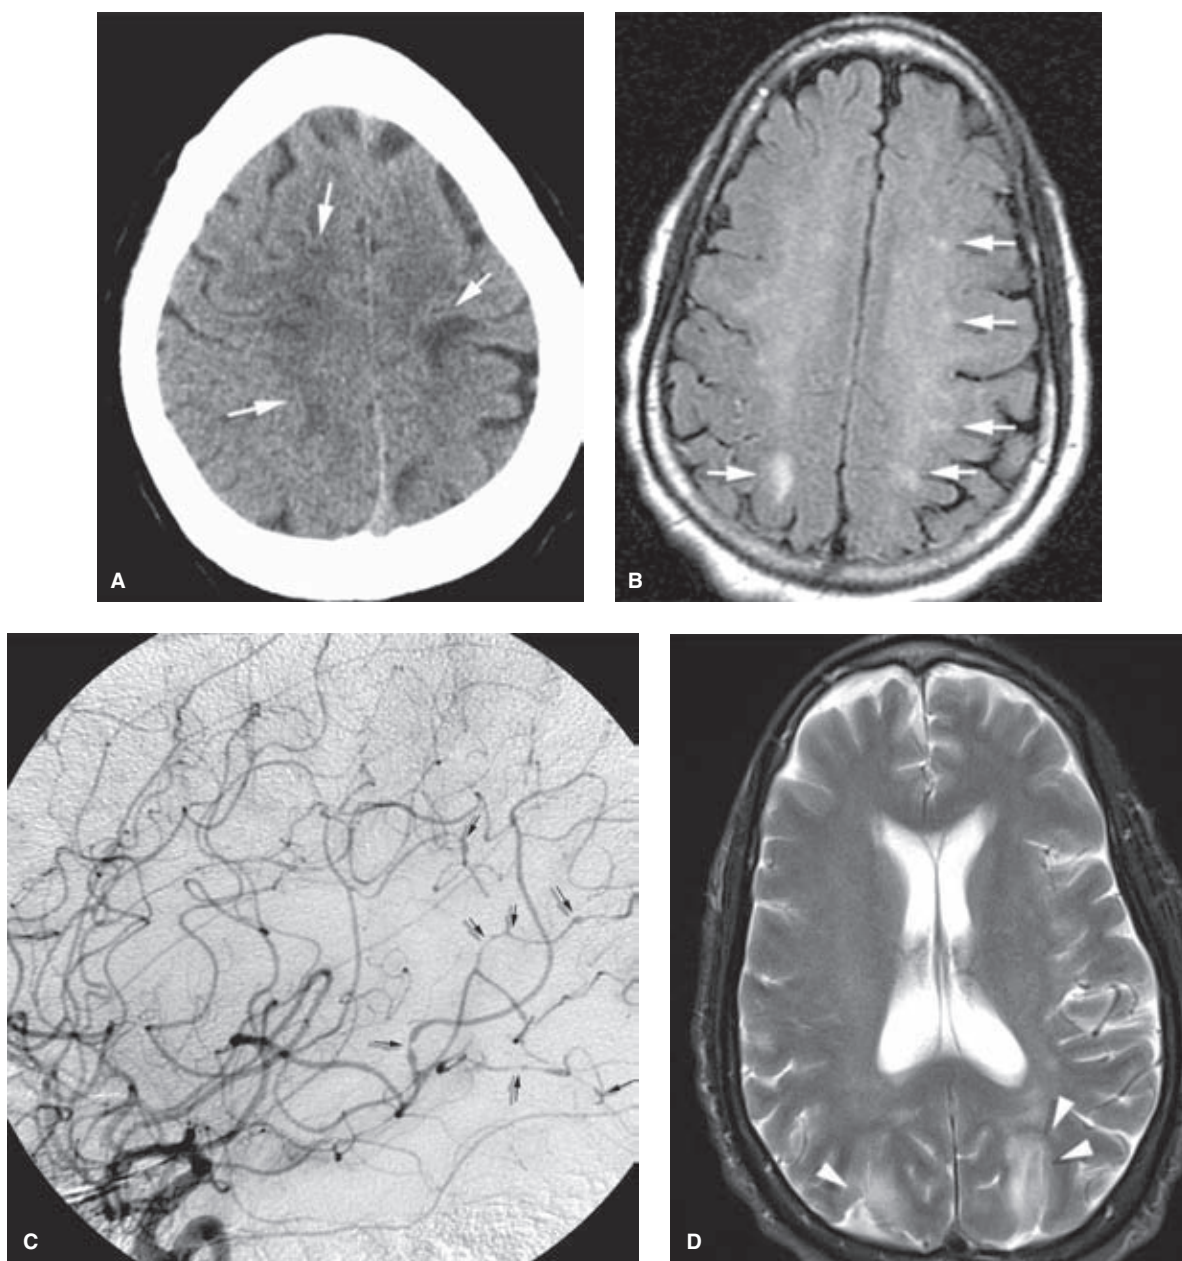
(A–D) RCVS associated with selective serotonin uptaker inhibitor use. A female patient in her sixties who had been prescribed an SSRI agent for treatment of depression presented with acute seizure and changes in mental status. During the diagnostic evaluation, her clinical condition and the extent of the imaging findings deteriorated on sequential examinations. Her CT (A) initially demonstrated nonspecific white matter lesions over the convexities (*arrows* in A), while FLAIR showed similar findings (*arrows* in B). Her initial angiogram (C) showed multiple irregularities (*small arrows* in C) in the left internal carotid artery territory and other vessels. Two weeks later her T2-weighted MRI (D) showed bilateral occipital lesions similar to those seen in PRES (*arrowheads* in D). Biopsy was considered, but cancelled when her condition finally began to improve, seemingly related to withdrawal of the SSRI medication. Her condition was ascribed to the SSRI agent, a recognized association and her improved clinical condition has been sustained without relapse. The long biologic half-life of most of the SSRI agents may be a factor in delaying recovery, as was the case in this patient.
